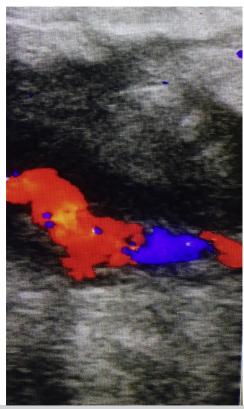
Follow-up duplex ultrasound examination of the right lower extremity. The right lower extremity bypass is widely patent at 1 year postoperatively.
